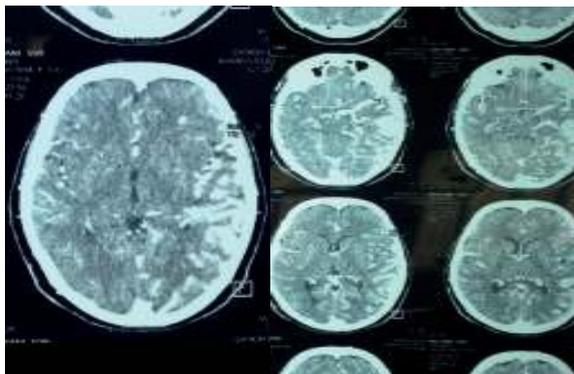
CT-Angio showing sub cortical left temporal lobe Arteriovenous Malformation.
